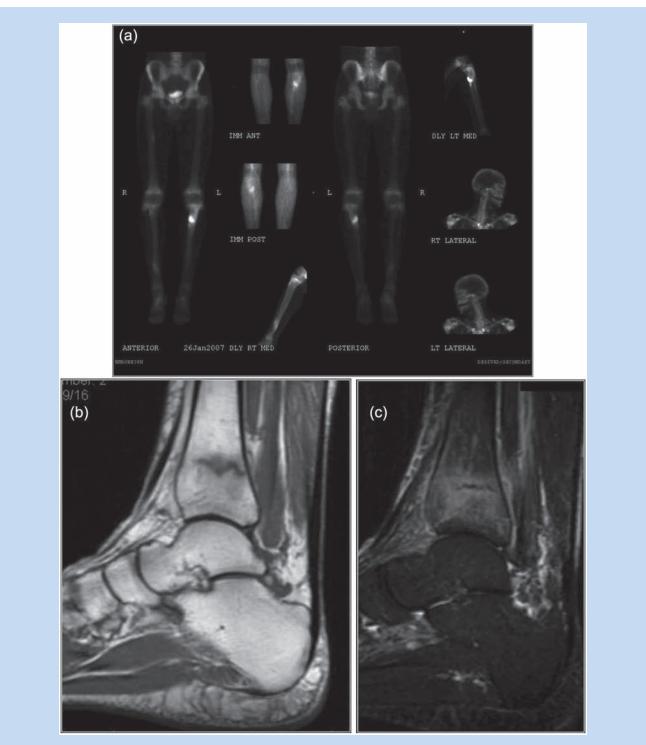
(a) Bone scan demonstrates increased tracer uptake in the proximal tibia in both immediate and delayed phase images consistent with a proximal tibial stress fracture. (b) and (c) Magnetic resonance imaging clearly shows a distal tibial stress fracture line on both T1 and T2 weighted images.
